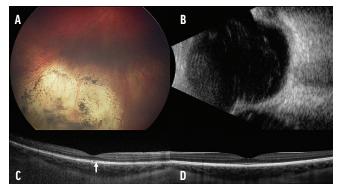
At 15-month follow-up. after four cycles of IAC and five cycles of intravitreal chemotherapy, there was complete regression of the tumor to a flat, calcified scar overlying a recent scleral buckle (A), which can also be seen on B-scan ultrasonography (B). On macular OCT, the fovea in the right eye was intact, but slight ellipsoid irregularity (arrow) was noted, likely accounting for the patient's visual acuity of 20/70 OD (C). Macular OCT in the left eve was normal (D).
